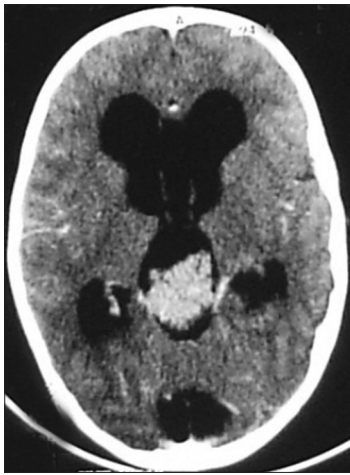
Preoperative contrast CT scan showing homogeneously enhancing mass in posterior third ventricle with hydrocephalus
